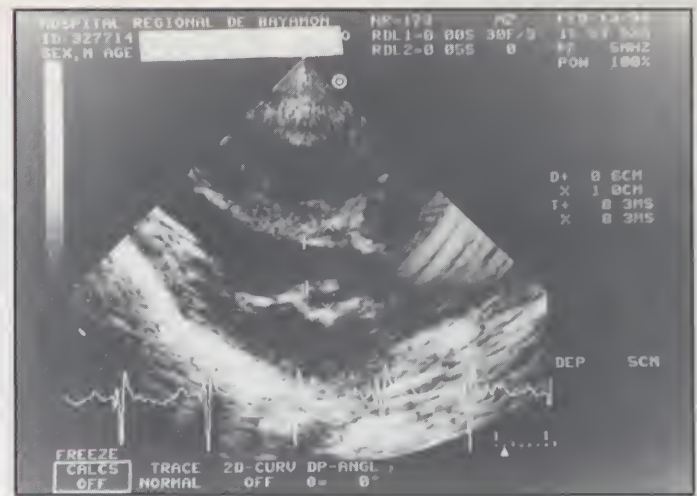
Parasternal long axis view, depicting measurements for the aortic valve annulus and root.
